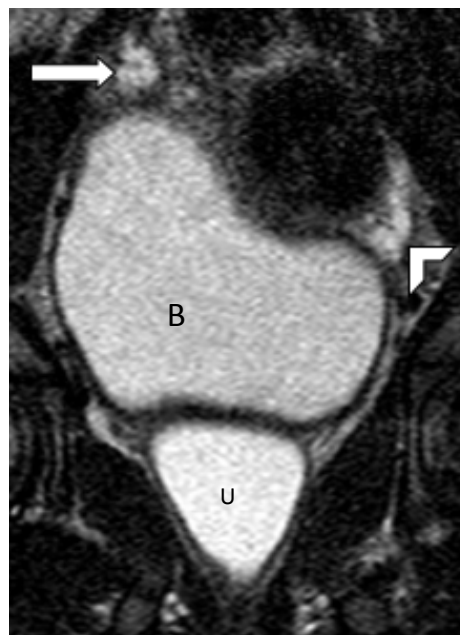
Coronal T2W MRI showing ovaries (long arrow and arrow head) and full urinary bladder (B) and fluid filled uterus (U)
